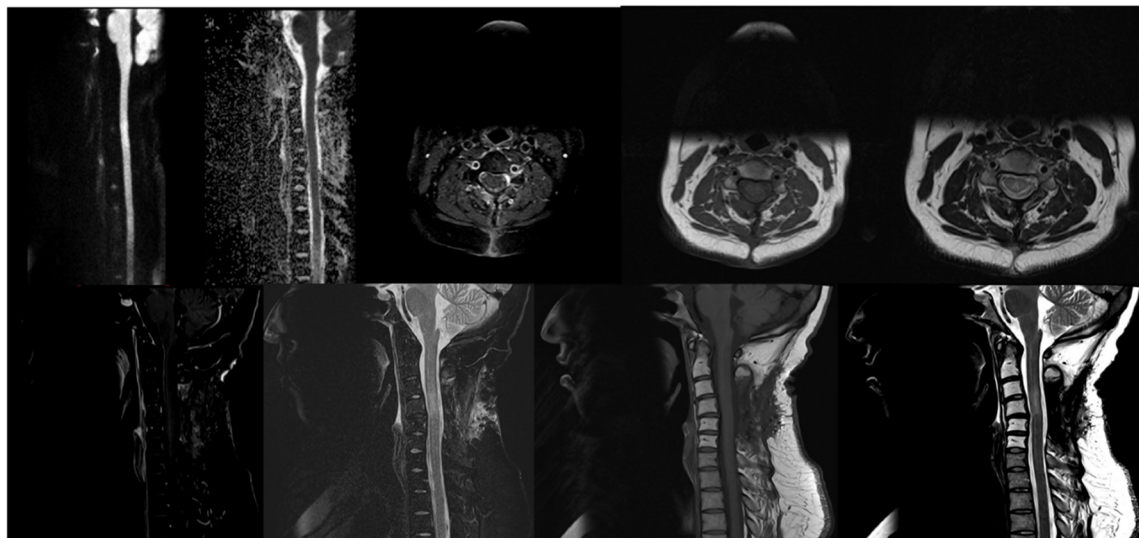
follow up MRI Showed that there has been interval laminectomy at C3-C5 levels, resolution of the large intraspinal anterior epidural mass on the ventrolateral aspect of the canal at the level of C3-C4, improvement of the signal alteration within spinal cord due to cord myelopathy, no significant diffusion restriction, stable faint mild enhancement of C4 vertebra and new alteration on T1 and T2-weighted images at C2 to C6 vertebrae related to radiotherapy.
